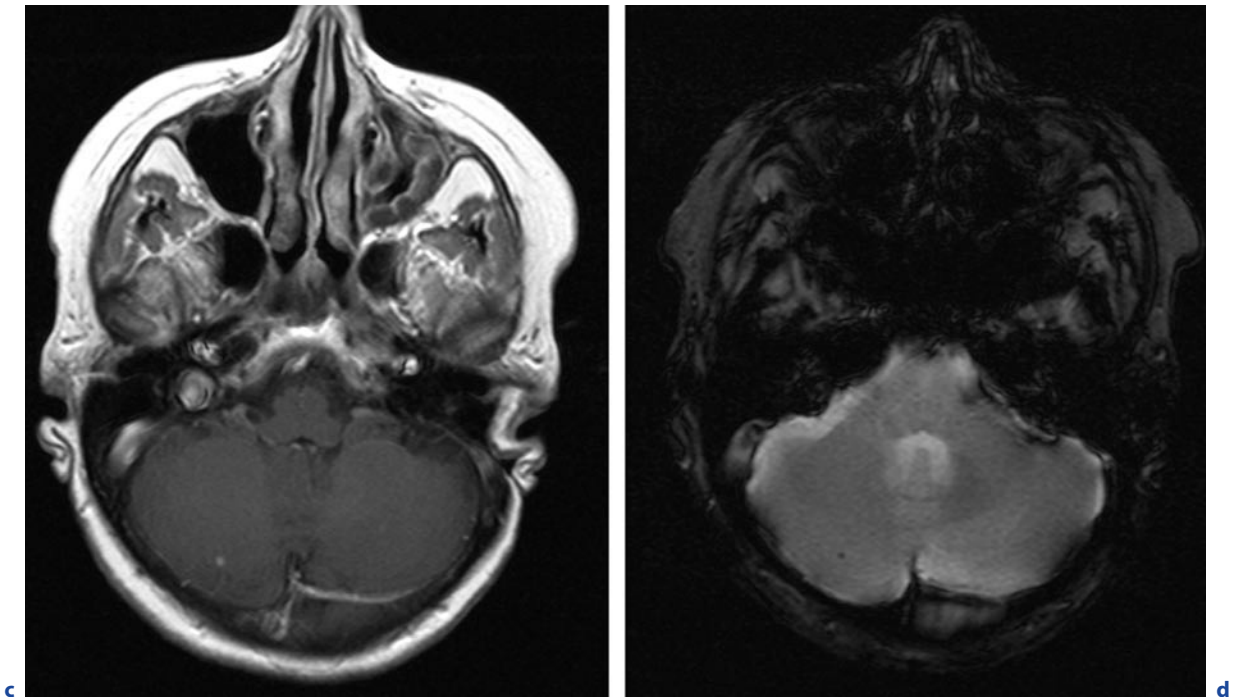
(continued) Brain abscesses due to *Nocardia* infection. A 60-year-old woman with amyloidosis who was immunocompromised after heart transplantation. c Axial T1-weighted images after contrast administration. d Axial T2*-weighted image. FLAIR image (b) reveals a hyperintense rim at the periphery of two small lesions with surrounding hyperintense edema in the right temporal lobe and the right cerebellar hemisphere. T1-weighted image after contrast administration
